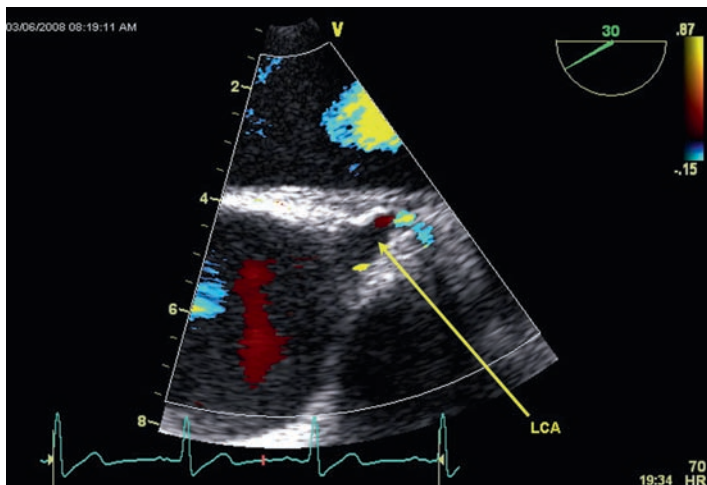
Mid esophageal aortic valve short axis view with color Doppler demonstrating flow in the left coronary artery (LCA).
